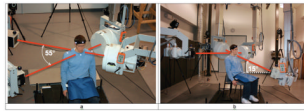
Biplane radiography system configuration for a) the flexion/extension trials, and b) the axial rotation trials. For flexion/extension trials, imaging systems were aligned horizontally and the angle between X-ray tube/image intensifier pairs was approximately 55° . For the axial rotation trials, the angle between imaging systems was 90° and the system imaging from anterior to posterior was tilted up 15° .
